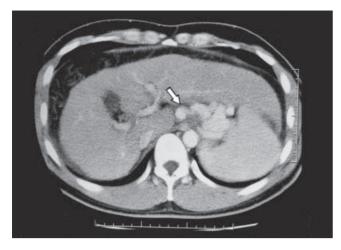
Left gastric vein (*arrow*), as the inflowing vessel, was detected with computed tomography (CT)
